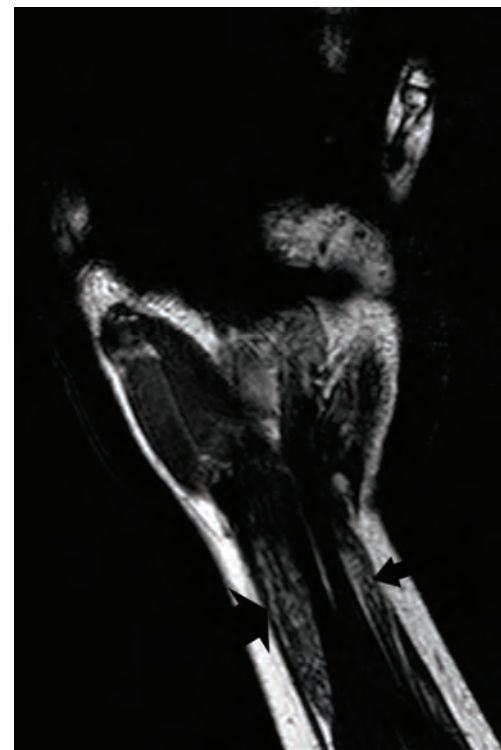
Coronal T1-weighted images of the wrist and distal forearm. The spaghetti-like appearance of both the median nerve (thick arrow) and ulnar nerve (thin arrow)
